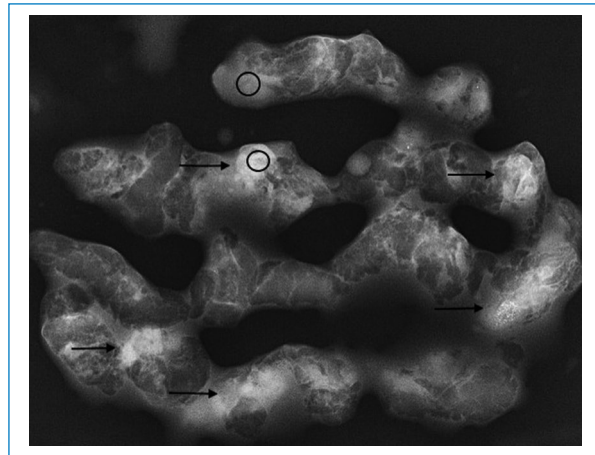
Example of a radiograph of samples obtained from a CEM biopsy. The arrows indicate dense areas that appear to contain iodine. The circles indicate where the densities were measured, with one region of interest (ROI) in the dense area and another in the less dense, but non-adipose area.
